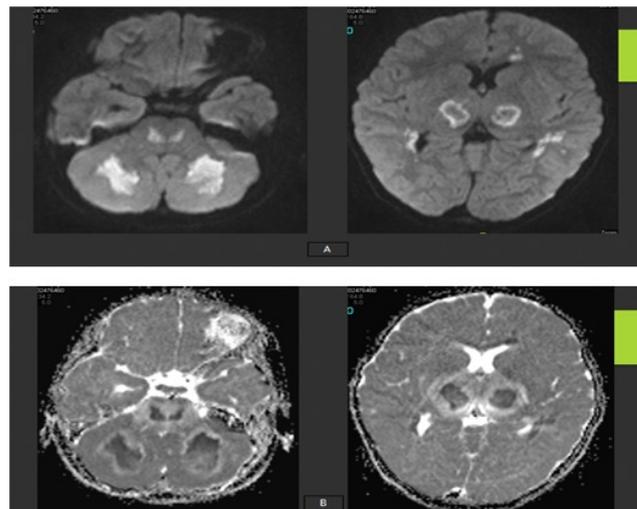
Axial DWI (A) and ADC map (B) MRI brain at the level of the pons, Basal Ganglia and Thalami showing bilateral rather symmetrical parenchymal areas of bright signal in DWI and low values in ADC maps denoting some element of restricted diffusion which also is seen involving the corpus callosum and the cerebellar white matter.
